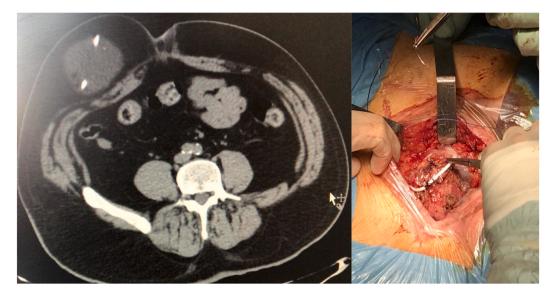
A. CT Abdomen: The Pre-operative abdomen CT scan shows the CSF abdominal collection in the subcutaneous tissue, where a catheter loop is depicted. B. Intra-operative surgical image of the distal catheter shunt insertion and fixation with stiches.
